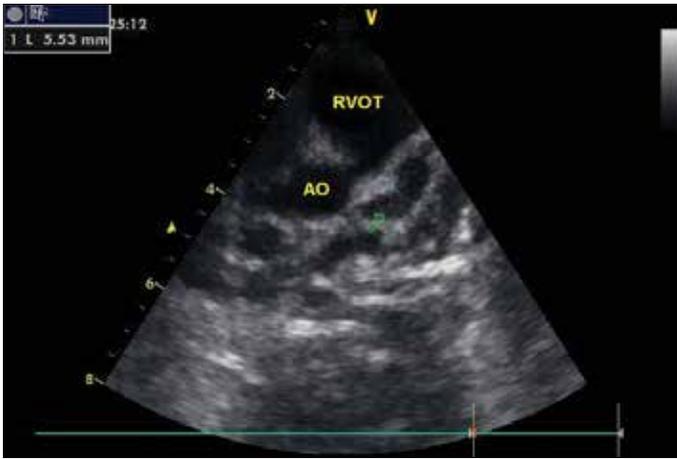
A 5.5 mm diameter aneurysm in LAD was observed at parasternal short-axis view in echocardiography
